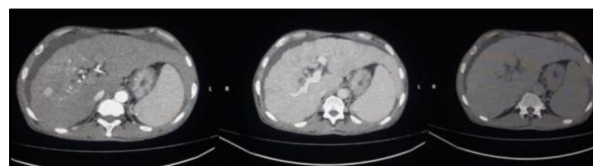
40-year-old Male Patient with HBV Cirrhosis, LR-5. An Arterial Phase CT Demonstrates a 16.8x13.4x13.5 mm (APxTRxCC) Non-Rim APHE Lesion in Segment 5 (arrow), Which Shows Non-Peripheral Washout in Both b Venous and c Delayed Phases (Arrows). The Lesion Was Categorized as LR-5 (HCC).
